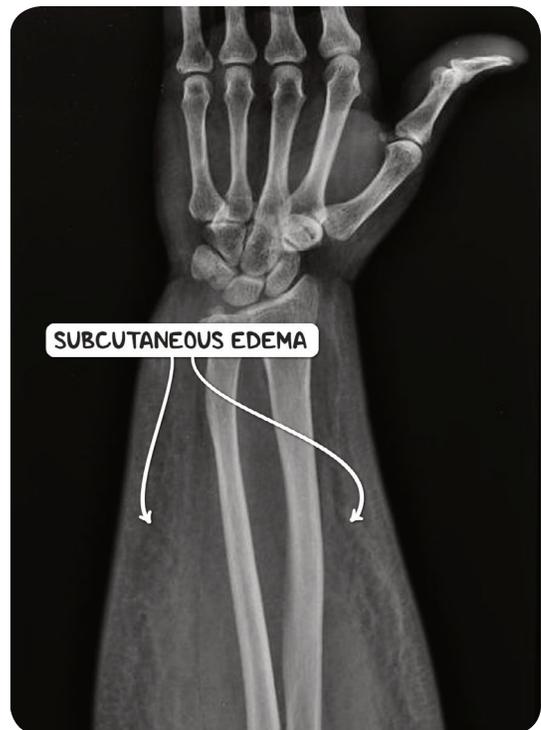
A plain X-ray of the forearm showing edema of the subcutaneous tissues. The subcutaneous fat shows characteristic streaky densities.
